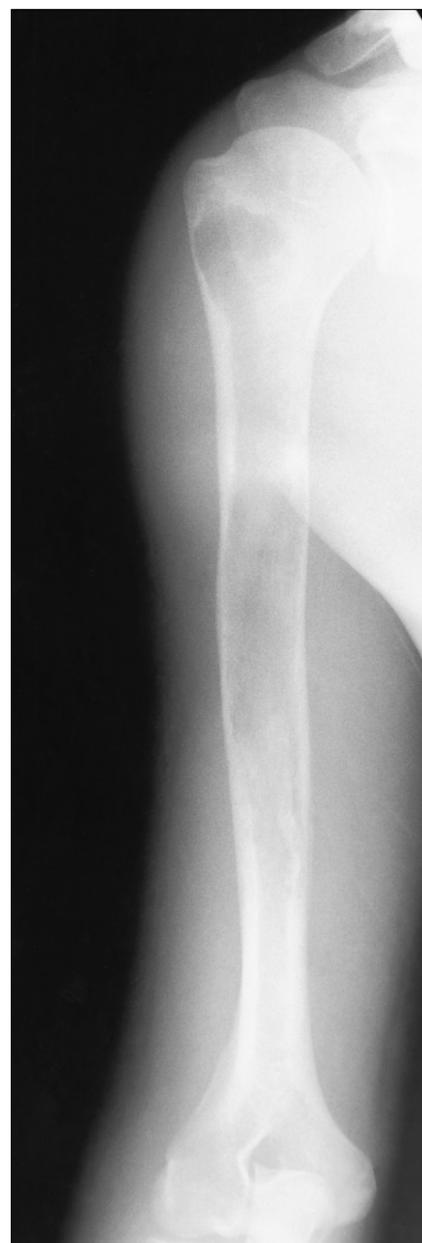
Plain radiograph of the right humerus.
